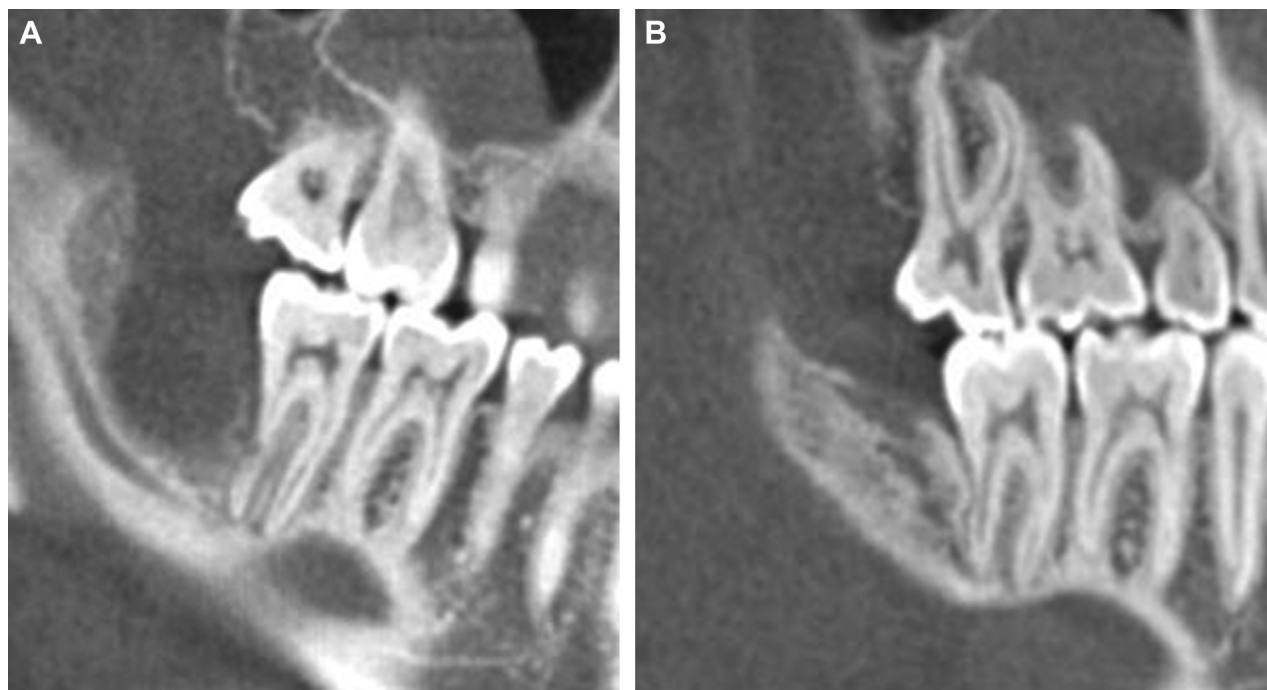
Sagittal cone-beam computed tomographic views A, before and B, after 15 doses of denosumab.
